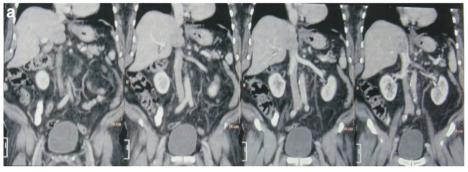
The CT scan imaging of the mass at a coronal and b axial axis
